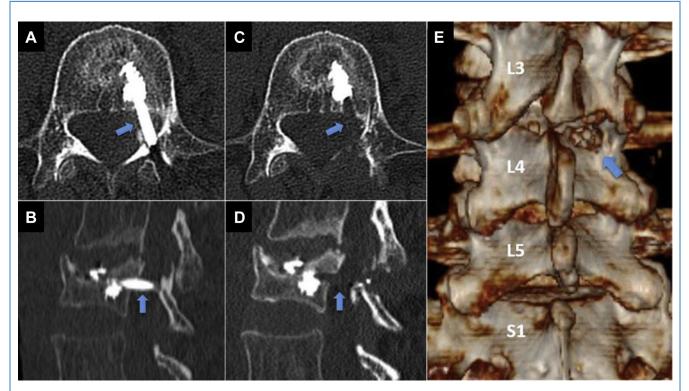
(A and B) Preoperative axial and sagittal computed tomography (CT) scan. Blue arrow shows cement fragment. (C and D) Postoperative axial and sagittal CT scan. Blue arrow shows cement fragment space after removal. (E) Postoperative 3-dimensional CT view. Blue arrow shows translaminar entrance window.
